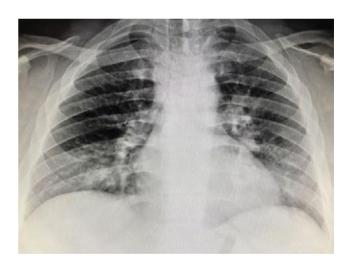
Chest radiograph 5 weeks after treatment with acyclovir. Improvement in infiltrative and consolidation processes at bilateral lung fields (Case 2).
